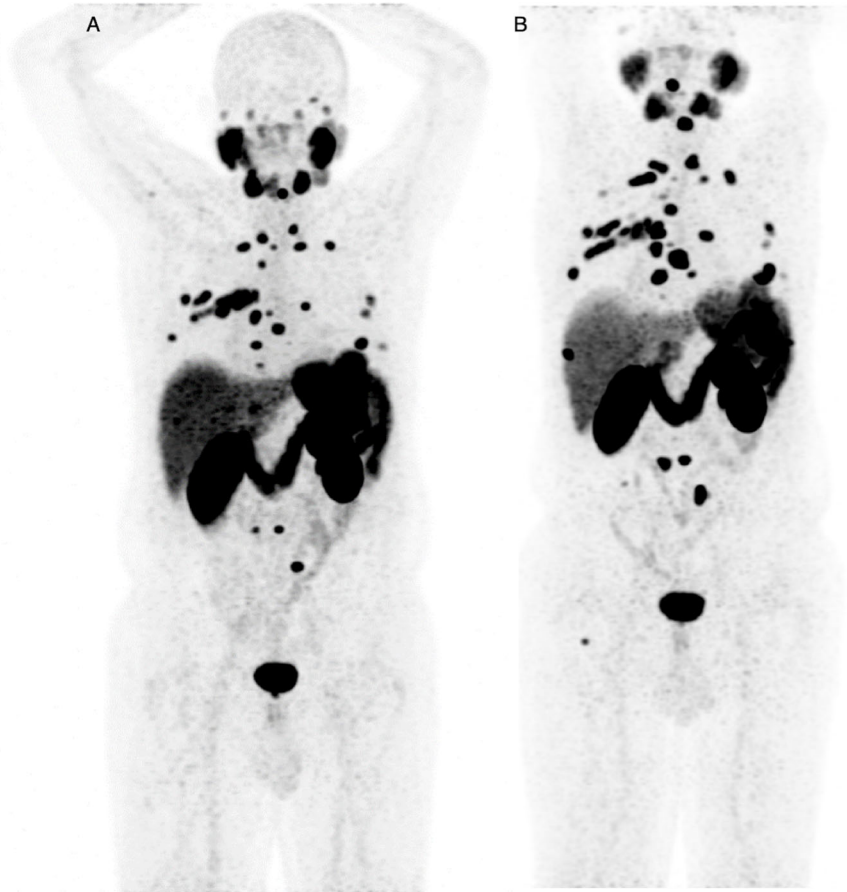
PPP for appearance of more than 2 new distant lesions. 70 years old patient who had a radical prostatectomy (Gleason Score 5+4, iPSA=7 ng/mL) plus adjuvant EBRT in 2009. In 2013 biochemical recurrence, treated with lymphadenectomy + ADT, castration resistance in 2017, with evidence of multiple bone lesions at PSMA PET (A). After enzalutamide, persistence of the previously evident lesions, with appearance of few new lesions (B) fulfilling the criteria of progression according to PPP.
